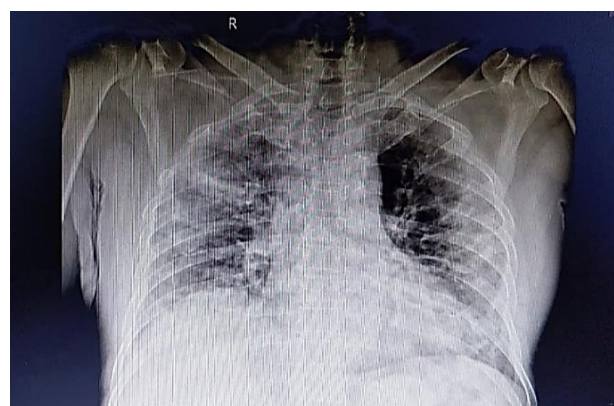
X-ray images of a typical patient with early-stage bilateral consolidation
